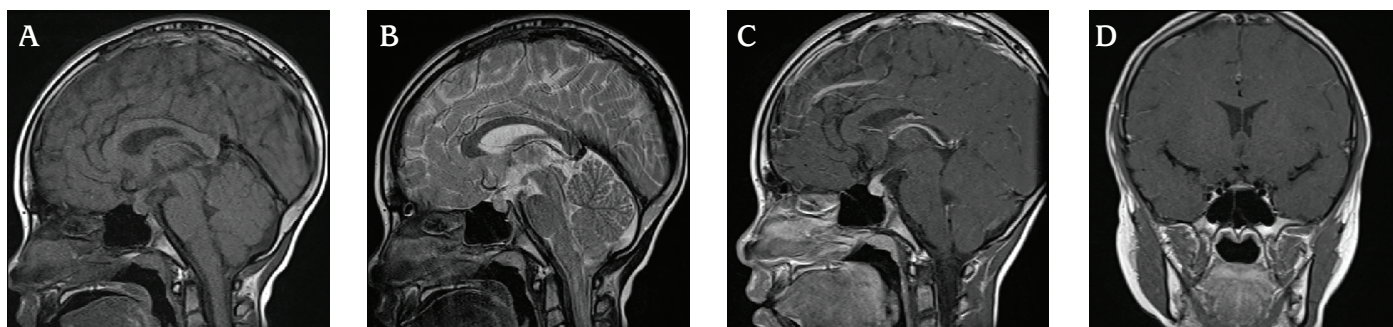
Pretreatment magnetic resonance images of the 8-year-old boy. A) Sagittal T1-weighted MRI at the time of diagnosis of CDI. B) Sagittal T2-weighted MRI at the time of diagnosis of CDI revealing loss of high signal intensity in the posterior lobe and enlargement of the pituitary stalk. C, D) Sagittal and coronal sections of T1-weighted contrast-enhanced MRIs at the time of diagnosis of CDI revealing a uniformly enhanced pituitary gland
